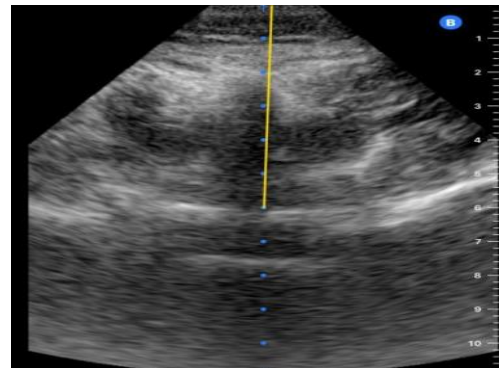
Epidural ultrasound Scanning
